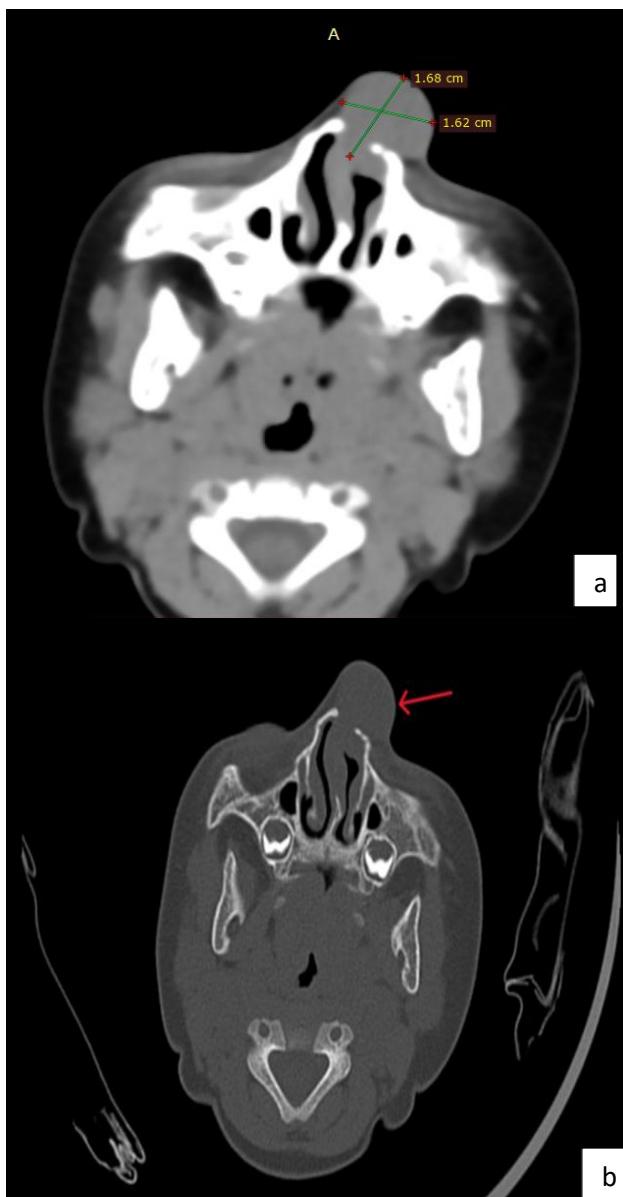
(a and b): CT reveals a well- circumscribed, non-enhancing nasal soft tissue mass without bony erosion or intracranial communication.
